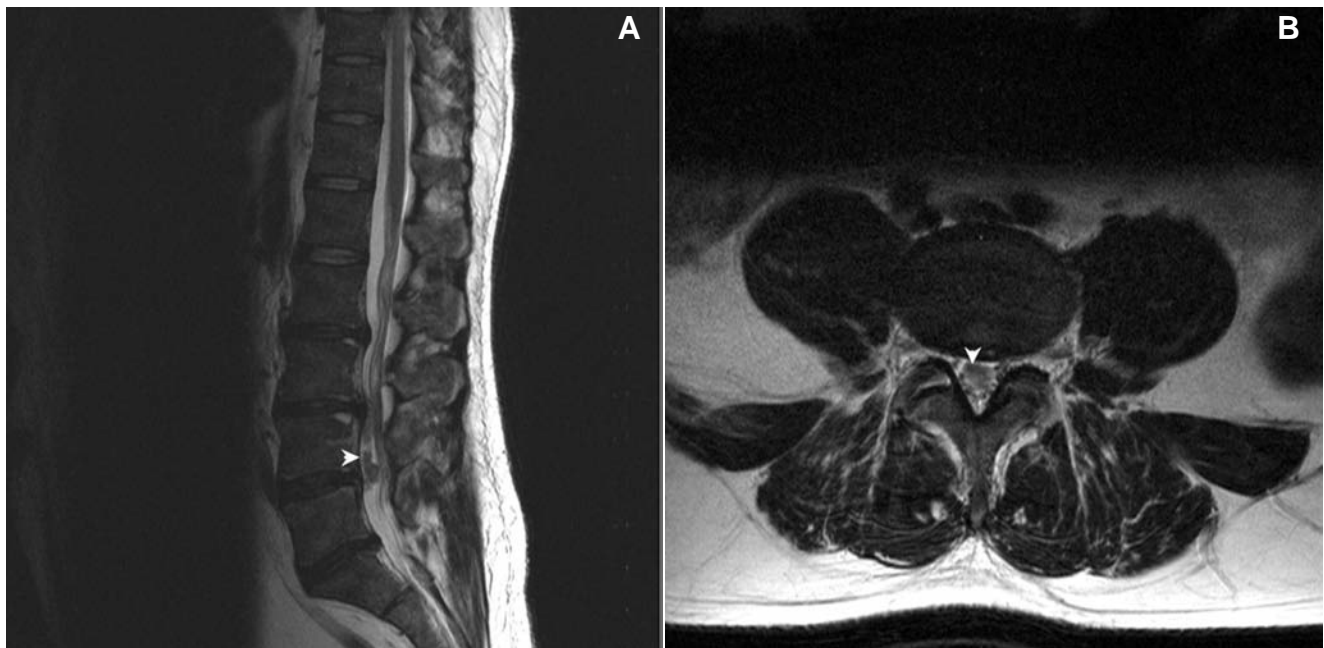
A) Sagittal T2-weighted image demonstrating the slightly hyperintense intradural lesion anterior to the nerve roots and extending inferiorly from the L3/4 level. B) Axial T2-weighted image again showing the anterior intradural lesion displacing the nerve roots posteriorly and laterally.
